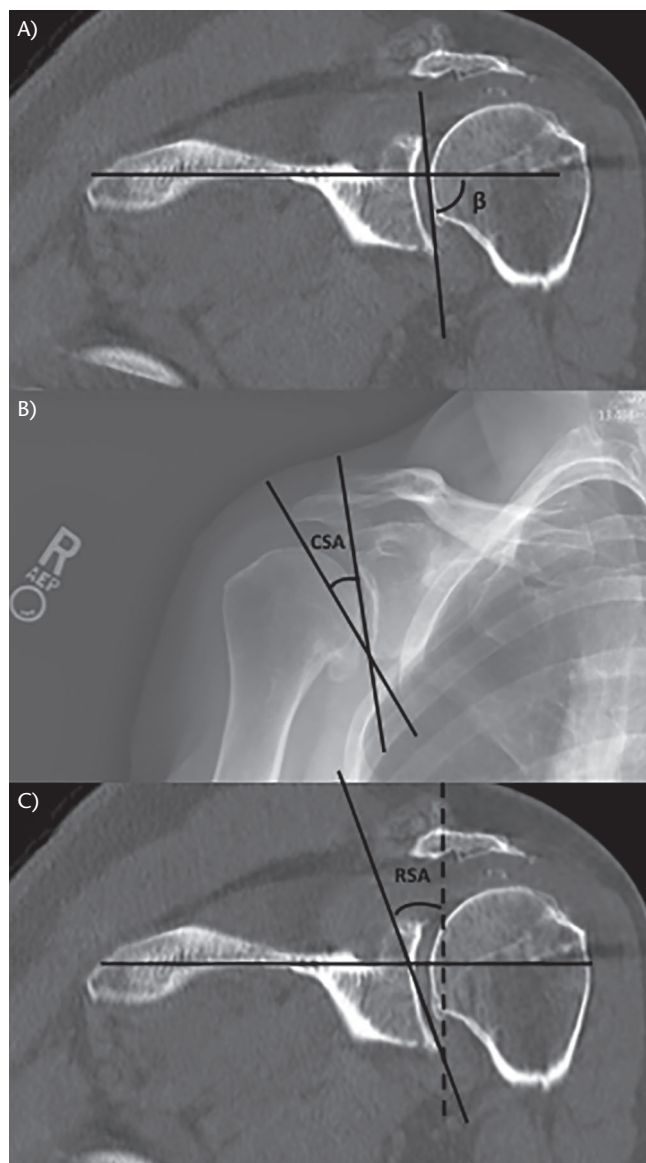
(A) Glenoid inclination as measured on a coronal CT of a left shoulder using the beta angle, which is the angle formed by the intersection of the glenoid line and the tangential line through the floor of the supraspinous fossa. The value of inclination is then calculated as the beta angle subtracted from 90. (B) The critical shoulder angle (CSA) shown on a true shoulder anteroposterior radiograph, defined as the intersection angle at the inferior glenoid margin between the glenoid line and the line drawn from the inferior bony margin of the glenoid to the lateral-most border of the acromion. (C) The reverse shoulder (RSA) angle measured on a coronal CT of a left shoulder, defined as the angle between the perpendicular (dashed line) of the tangential line through the floor of the supraspinous fossa and the line through the inferior glenoid fossa (connecting the inferior glenoid rim to the intersection of the supraspinous fossa tangential line and the glenoid rim).
